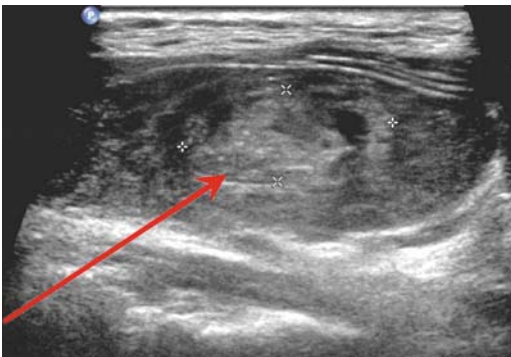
Intrathyroidal parathyroid. This patient's USS, MIBI, and CT were negative after failed initial exploration. USS had showed a thyroid nodule (above) with follicular cytology. At reexploration the right inferior gland was missing and a thyroid lobectomy showed an intrathyroidal parathyroid gland cured the patients' persistent hyperparathyroidism. (Courtesy of Dr. Catherine Clout, Consultant Radiologist, Northern General Hospital, Sheffield).
